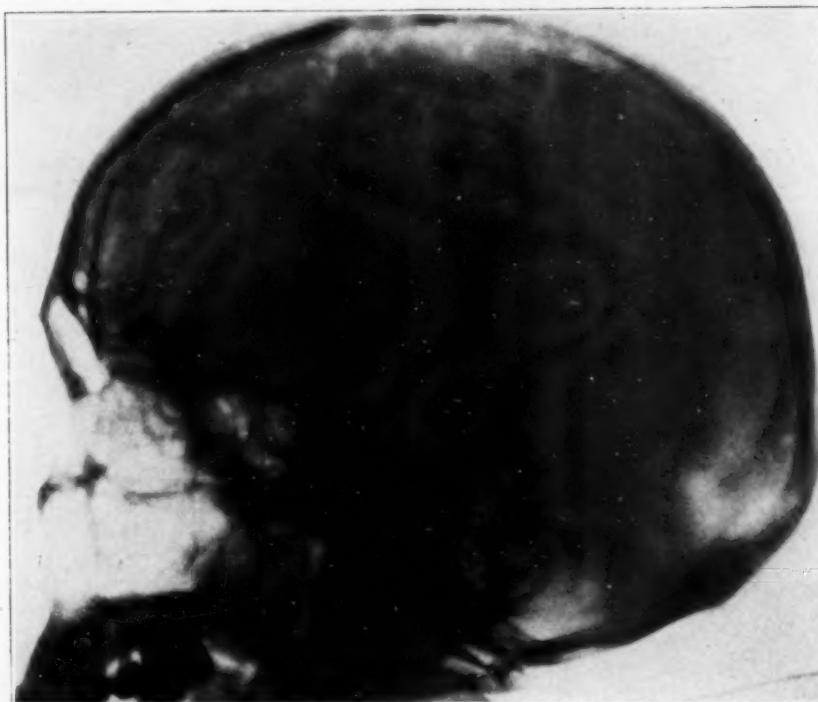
Roentgenogram of the skull of a patient with cerebral thrombosis and a large mass of veins on the cortex of the brain.
